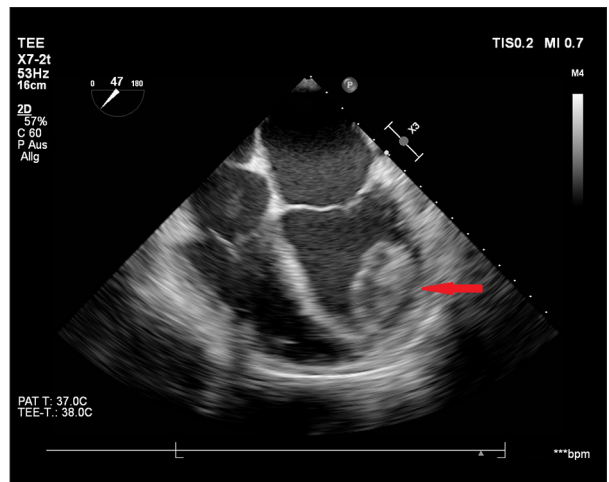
Thrombus adherence to LV wall: Apical 4-chamber view of the left ventricular thrombus with deep septal and trabecular position.
